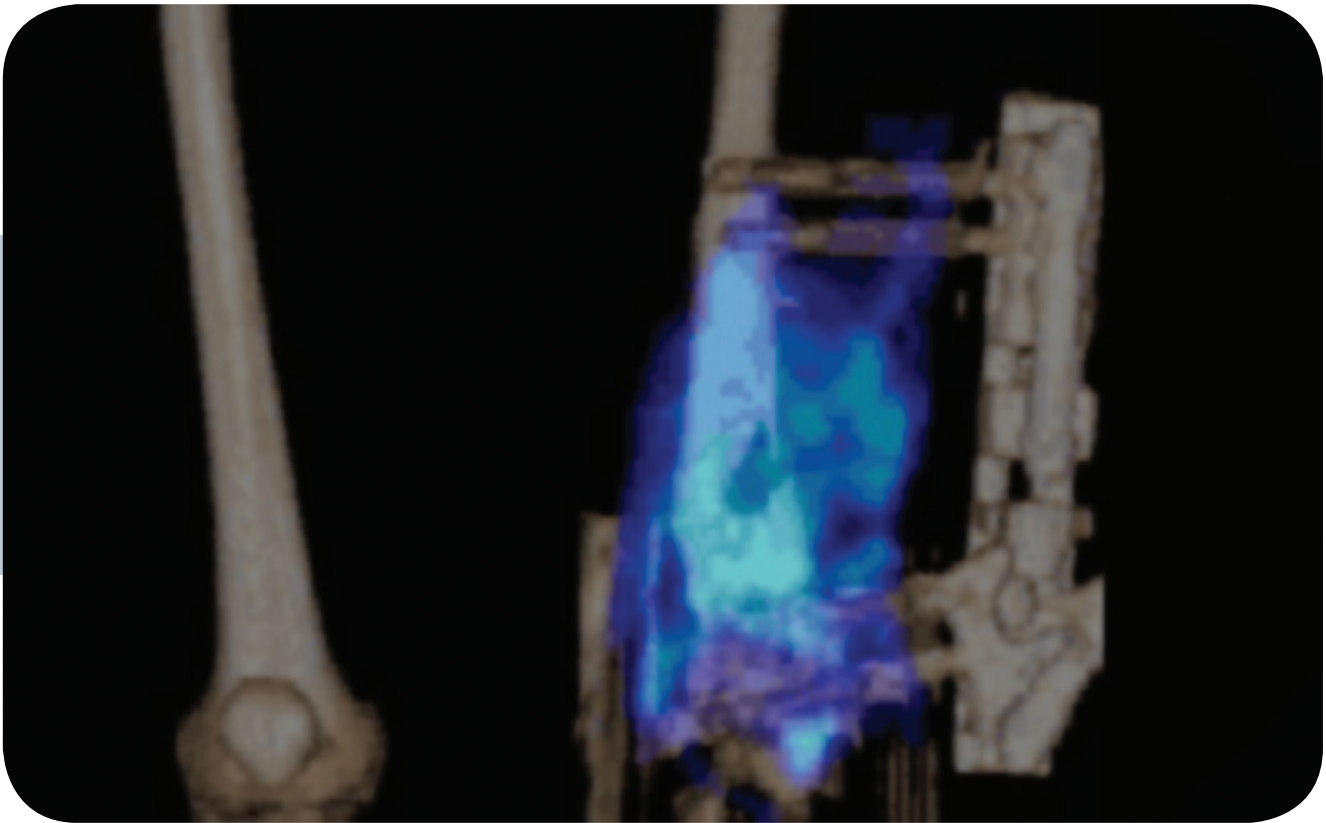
SPECT / CT study of a patient with infection associated to fastening material, in which focal radiotracer uptake seen in bone and soft tissue is consistent with osteomyelitis (INCan, 2012).
